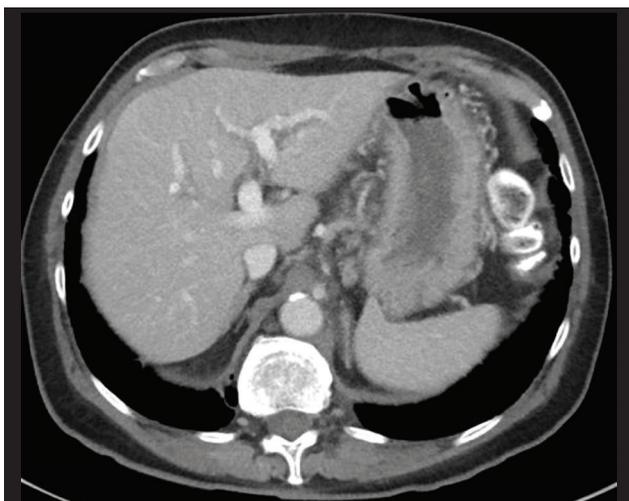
Diffuse Thickening of the Stomach on Computed Tomography Scan of the Abdomen
